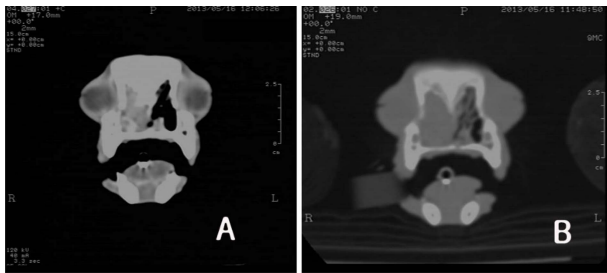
Soft tissue transverse contrast CT enhancing image (A) and bone transverse CT image (B). Soft tissues were found in the entire right nasal cavity, part of the left cavity, and also in the frontal sinuses which were suspected to be a nasal mass (A). Bone lyses were found not only in the cranial nasal turbinate, but also in all of the right ethmoidal bones and caudally bilateral.
